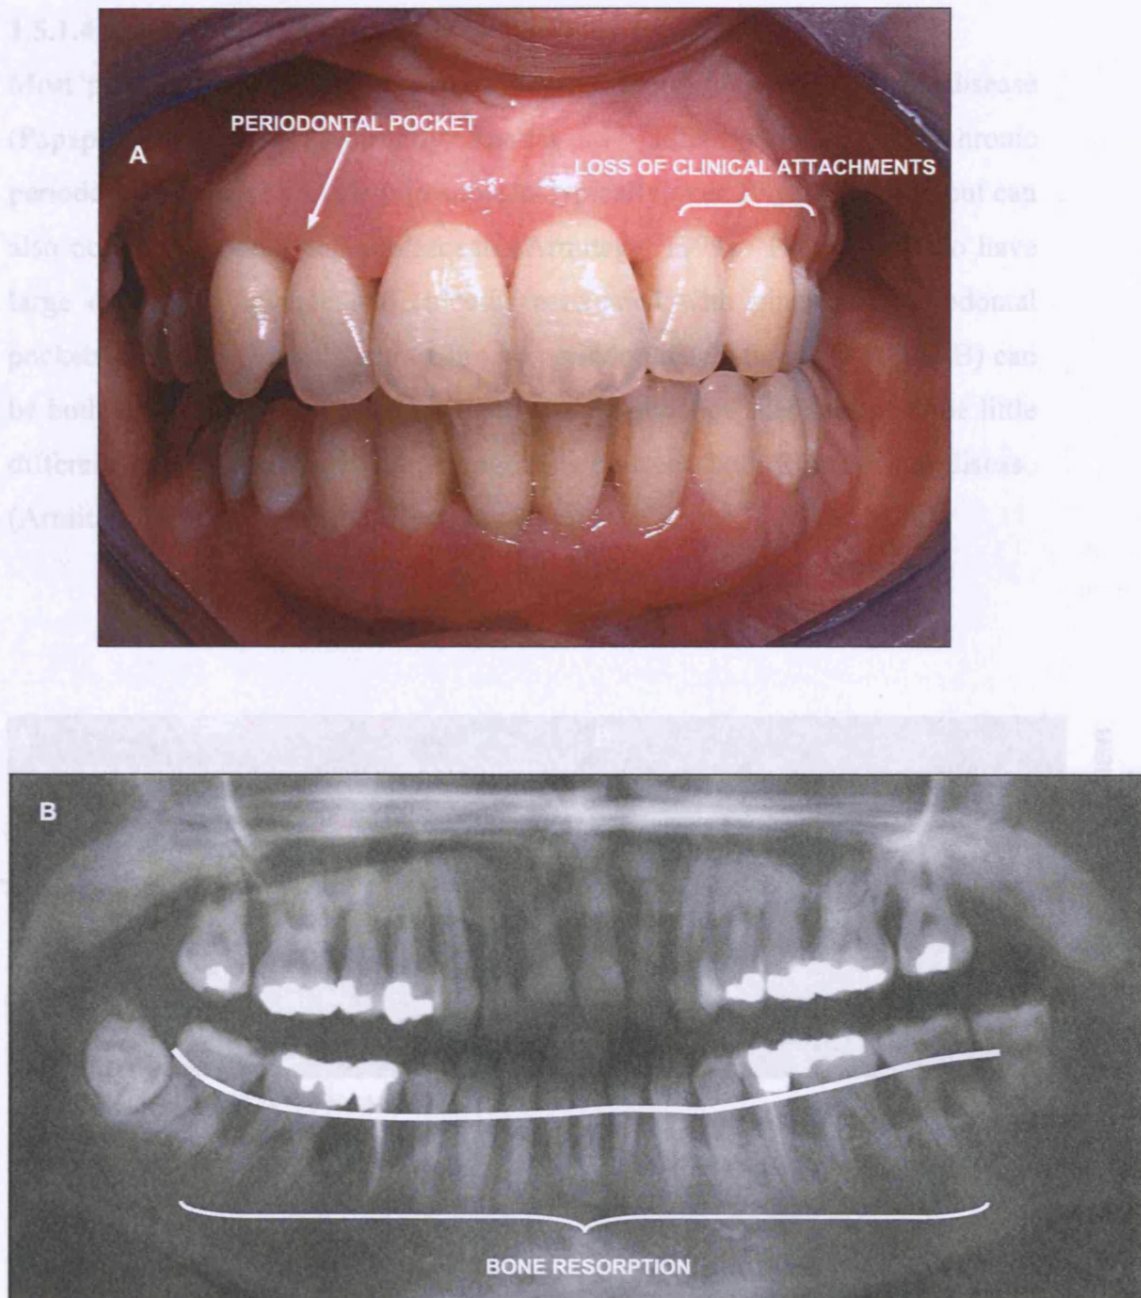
(A) Clinical photograph of generalised aggressive periodontitis (GAP): In a patient younger than 30 years of age, periodontitis in this case is not confined only to the incisors and first molars. (B) Panoramic radiograph of GAP. Demonstrating bone resorption associated with most teeth. A white line has been inserted to approximately demonstrate where the bone should be in a healthy subject (photographs kindly provided by Luigi Nibali)
